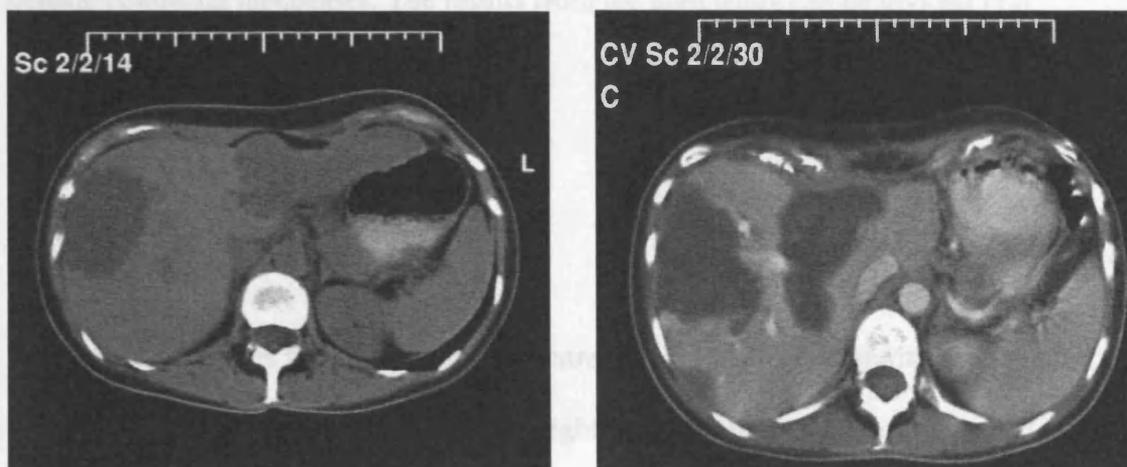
Patient with multiple, large, bi-lobar metastases seen on the pre-operative CT (left) was treated with a left lateral bisegmentectomy and multiple ablations in the right lobe. The post-operative CT (right) is seen at 3 months post procedure and shows complete ablation of the lesions with no hepatic recurrence noted.
